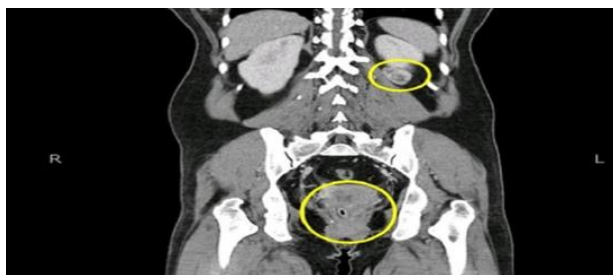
(Abdominal And Pelvic Tumor in CT)
